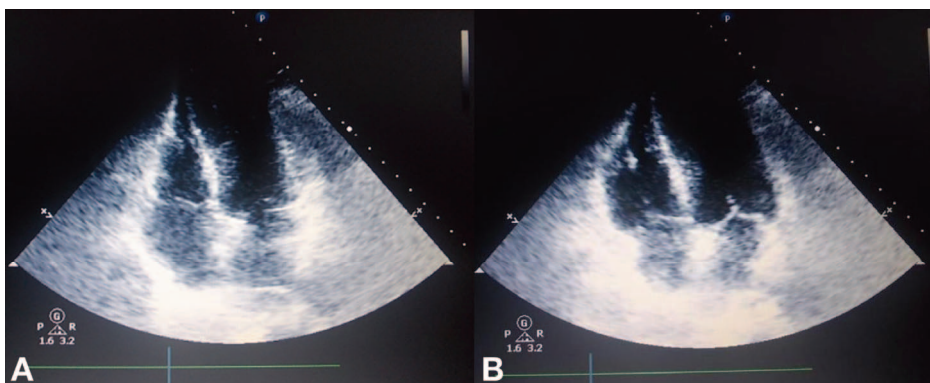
Transthoracic echocardiogram (apical 4-chamber view) 9 days after subarachnoid hemorrhage attack showing better apical contractility of left ventricle in systole (A) and in diastole (B).
